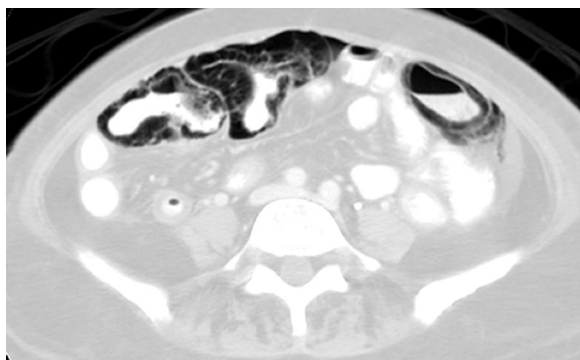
Benign pneumatosis intestinalis following stem cell transplantation. Contrast-enhanced CT scan (lung window) demonstrates pneumatosis intestinalis.
